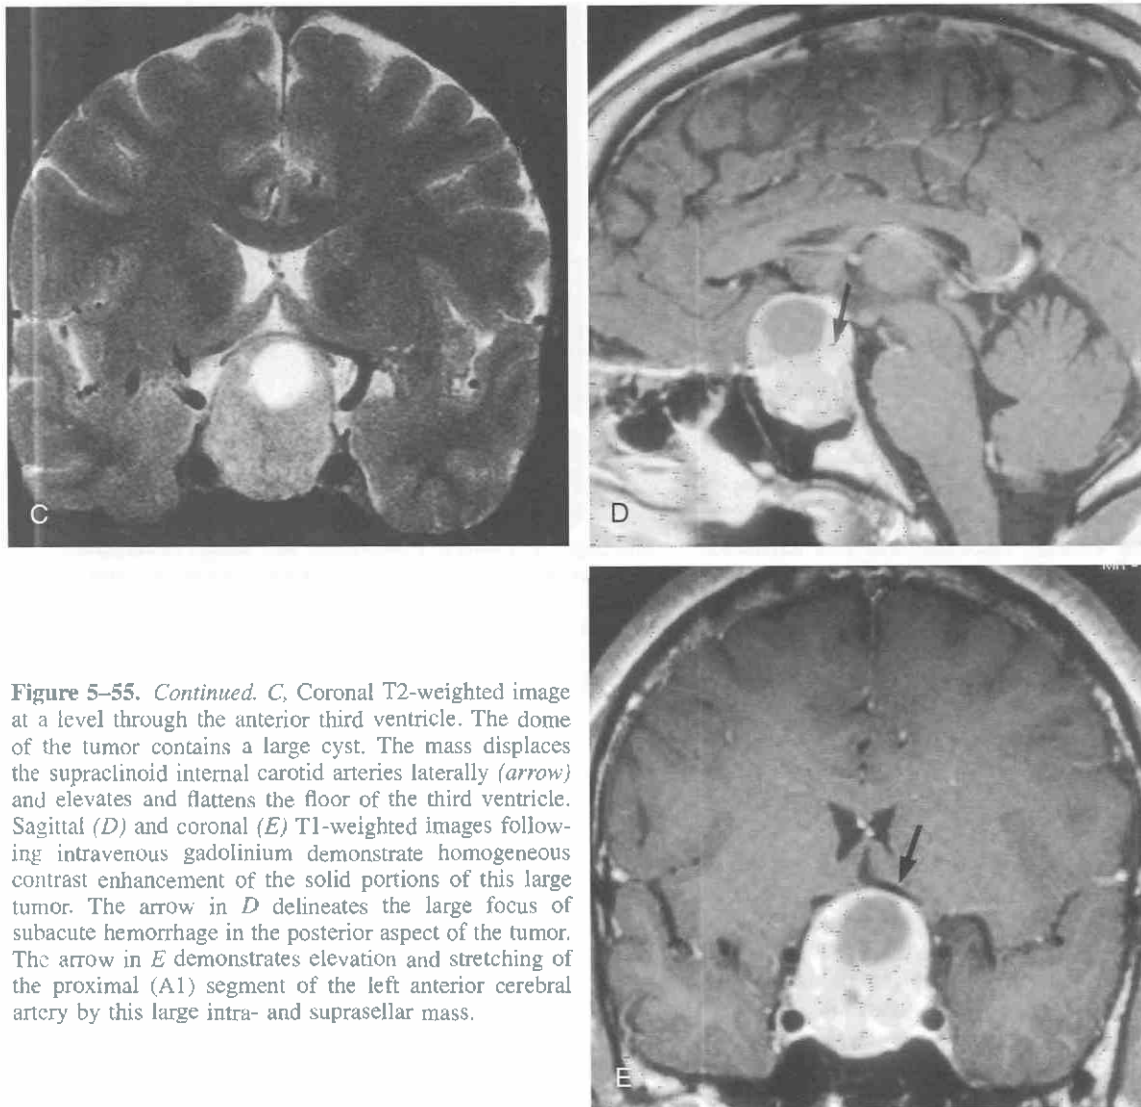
Continued.* C, Coronal T2-weighted image at a level through the anterior third ventricle. The dome of the tumor contains a large cyst. The mass displaces the supraclinoid internal carotid arteries laterally (arrow) and elevates and flattens the floor of the third ventricle. Sagittal (D) and coronal (E) T1-weighted images following intravenous gadolinium demonstrate homogeneous contrast enhancement of the solid portions of this large tumor. The arrow in D delineates the large focus of subacute hemorrhage in the posterior aspect of the tumor. The arrow in E demonstrates elevation and stretching of the proximal (A1) segment of the left anterior cerebral artery by this large intra- and suprasellar mass.
